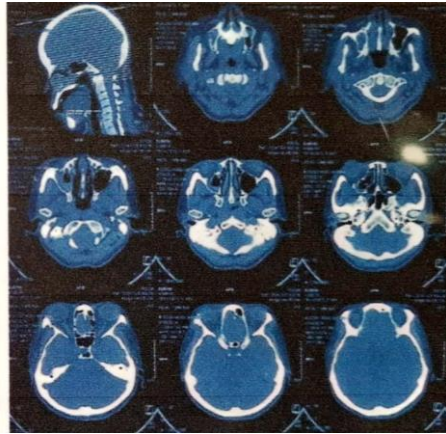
Head CT scan in hospital
